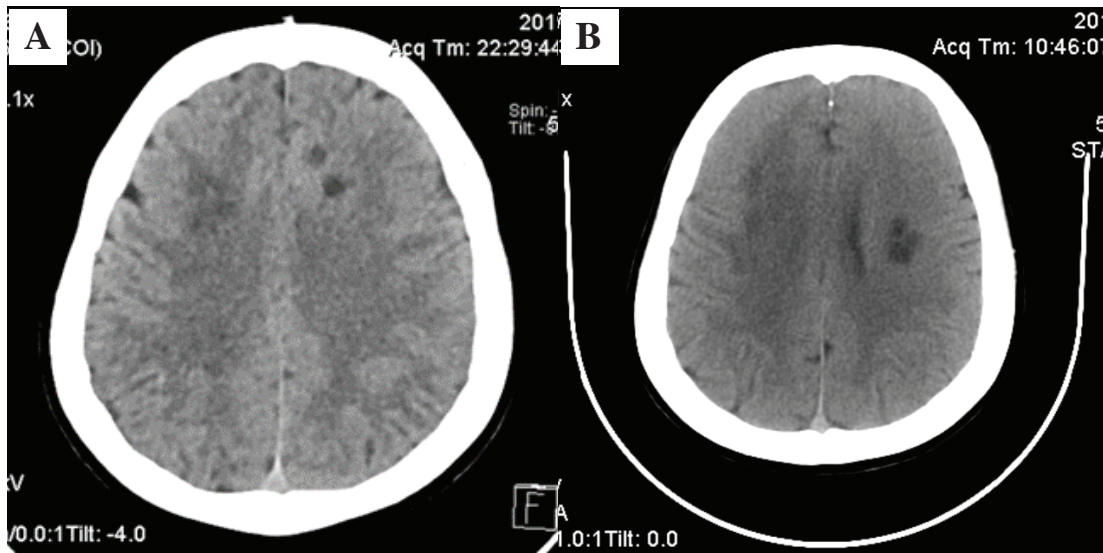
CT (brain) of the patient. A. Axial image showing bilateral multiple hypodense lesions. B. Appearance of new lesions over left central semiovale on repeat scan 3 weeks after first admission with development of right hemiparesis.
